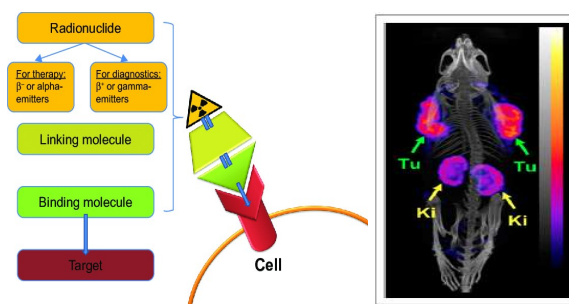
Left Simple outline of the theranostic. Right SPECT with radioisotopes (Muller, C., et al . *Journal of Nuclear Medicine* 55(10):1658–64).
